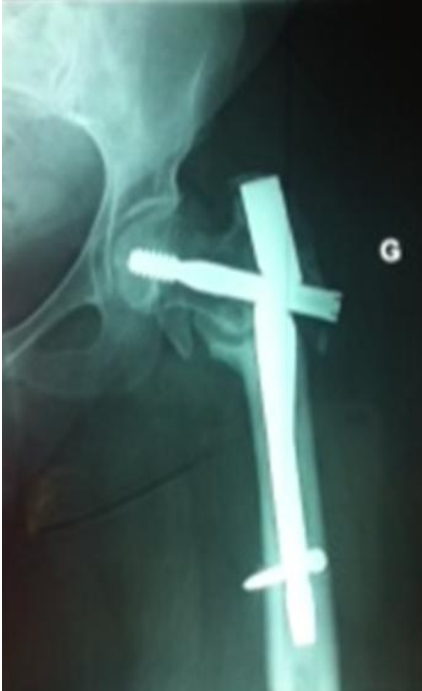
Antero-posterior radiograph of the left proximal femur showing the union of the fracture
